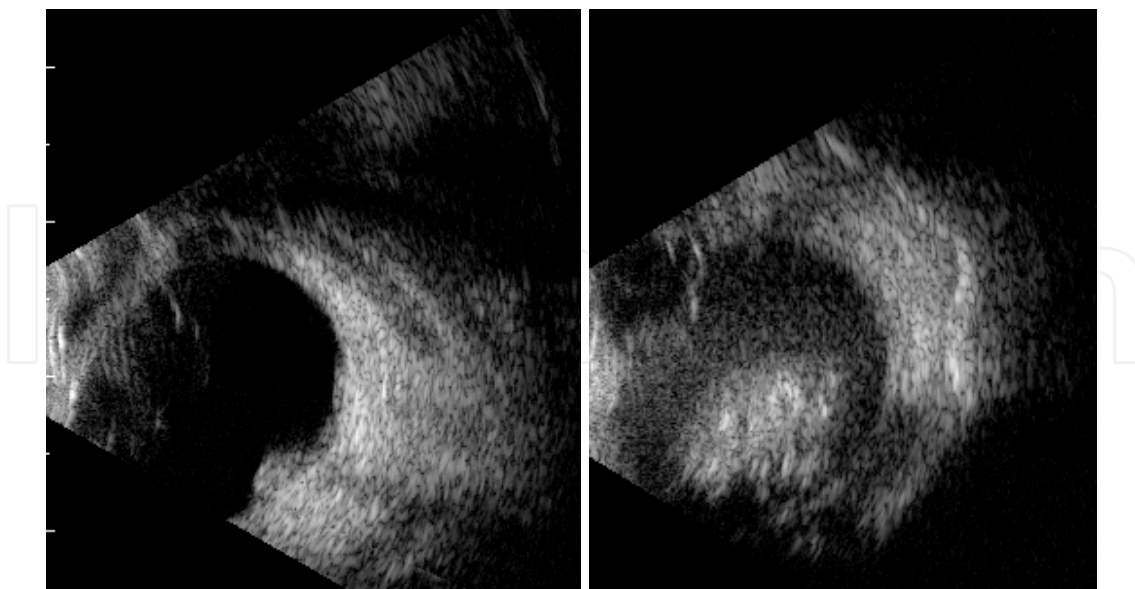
B scan ultrasonography of right and left eye of same patient at time of presentation in December 2011 showing multifocal tumors in the right eye, and the left globe filled with large tumor
